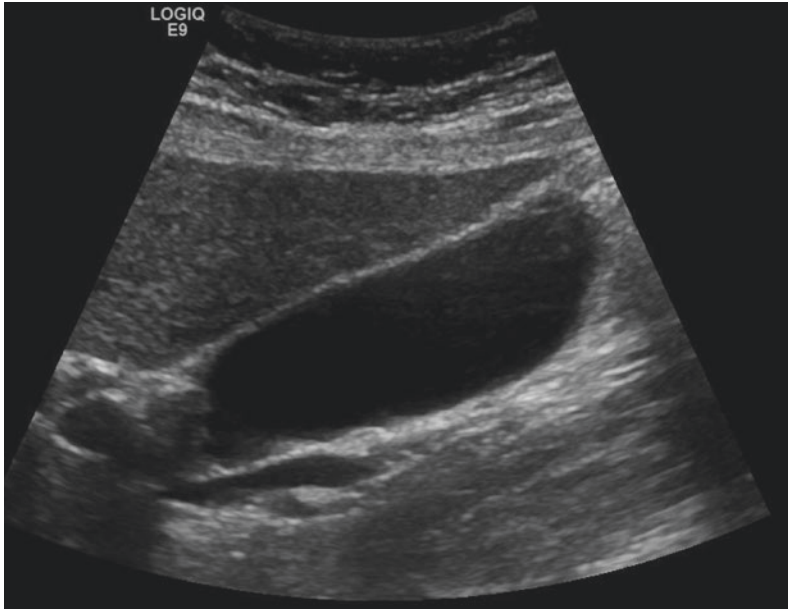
Gallbladder ultrasound image, using a a high frequency probe (9 MHz), and b a conventional frequency probe (1–5 MHz) in a 55-year-old male. Thickening of the gallbladder fundal wall and layers are observed more accurately and clearly with the high frequency probe (a) than the conventional probe (b)
